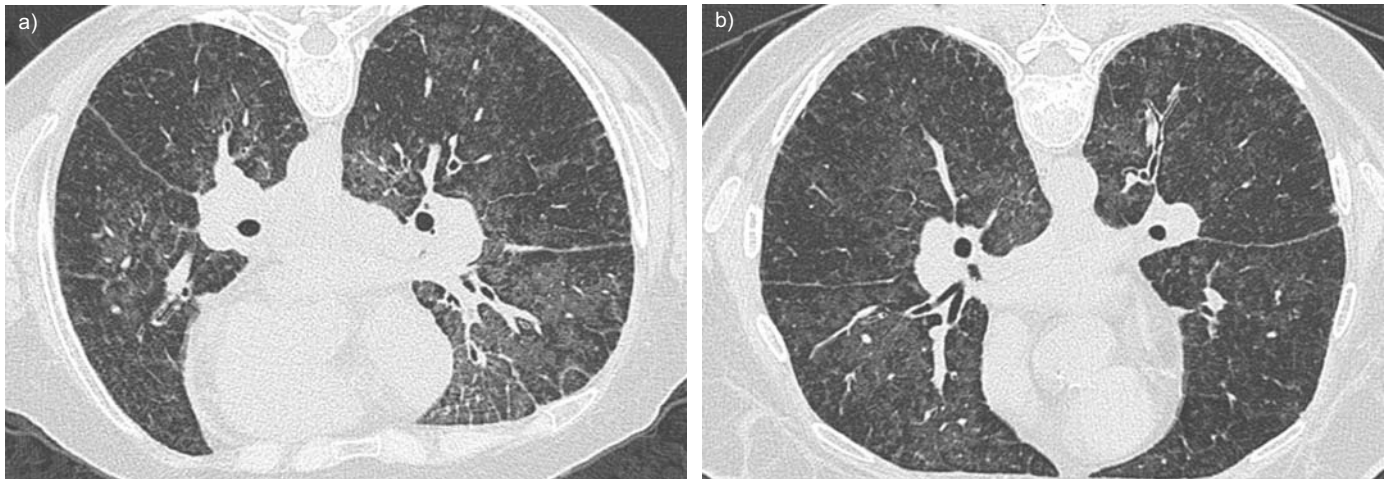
High-resolution computed tomography scan of the lung, demonstrating a) thickened lobular septal lines and patchy mosaic ground-glass opacities before treatment with imatinib and b) persisting ground-glass opacities but decreased lobular septal thickening after initiation of imatinib.
